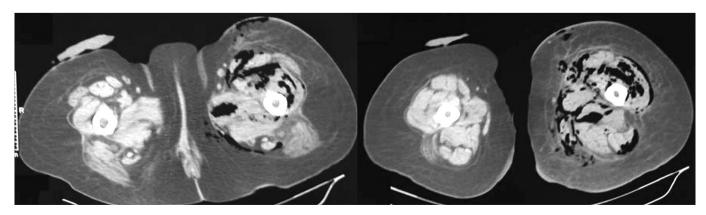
CT scan demonstrating increased diameter of the left thigh compared to the right and presence of gas both in the subcutaneous tissue and also between the muscles.
